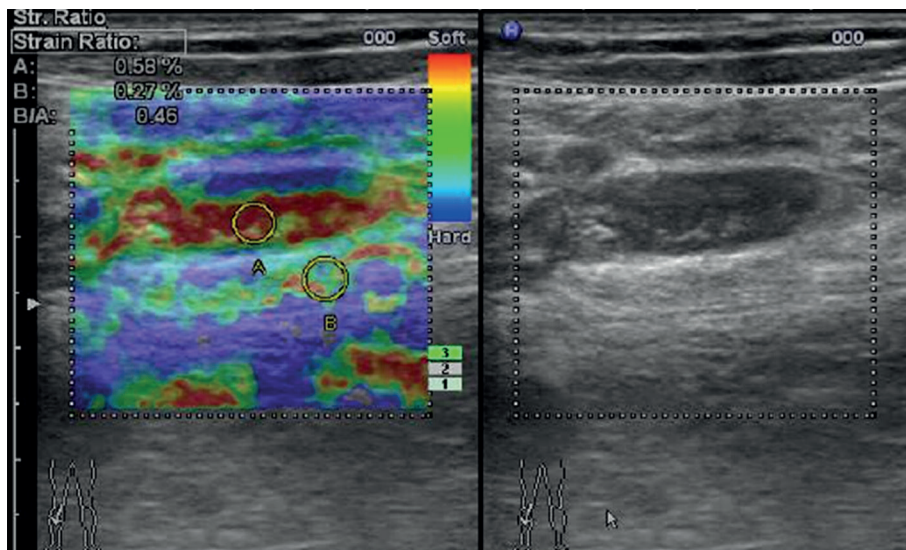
Ultrasound elastography image of acute thrombosis.
